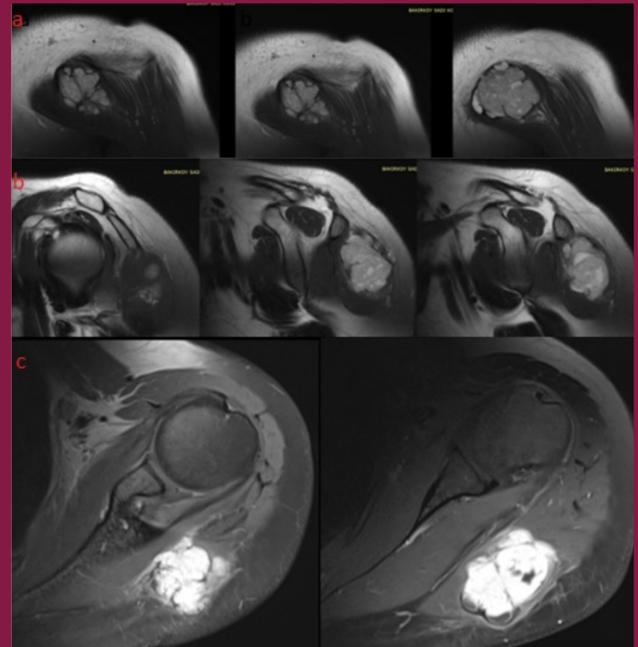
a-c. Magnetic resonance images of the lesion from different views
